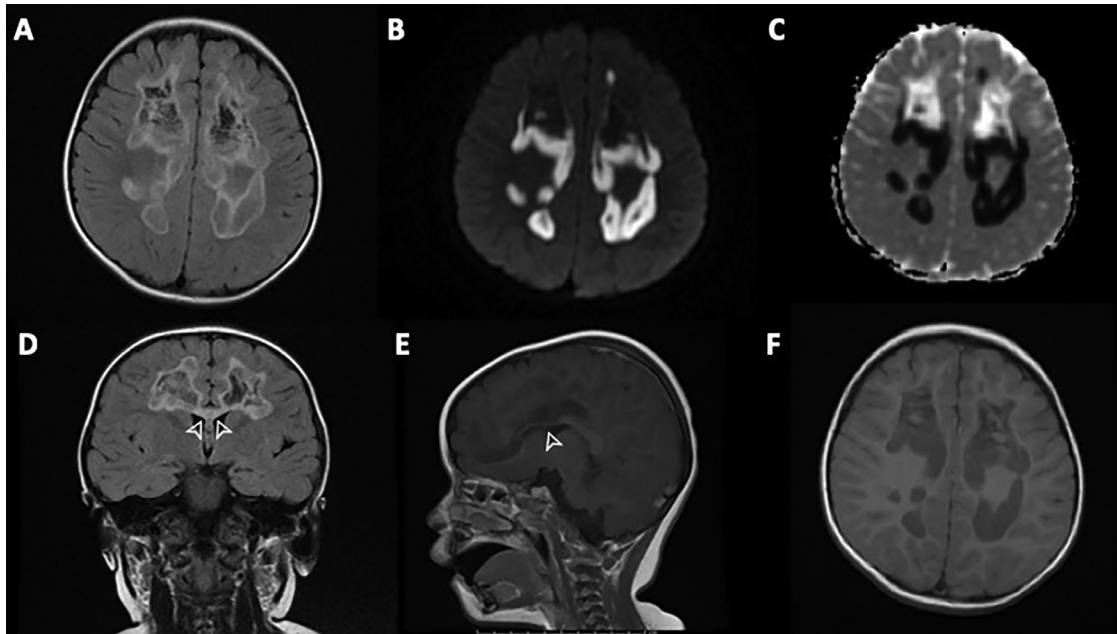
Brian MR images at 2 years and 4 months of age. A and D, Axial fluid-attenuated inversion recovery (FLAIR) image (A) and coronal FLAIR image (D) demonstrates a bilateral leukoencephalopathy with central cavitation and hyperintense rim involving the centrum semiovale and anterior corpus callosum (arrowheads). B and C, Axial diffusion-weight image (B) and apparent diffusion coefficient map (C) shows restricted diffusion in the peripheral portion of the affected white matter with increased diffusivity in the cavitations. E, Sagittal T1-weighted image shows involvement of the anterior corpus callosum (arrowhead). F, Axial T1-weighted image demonstrates sparing of the subcortical white matter (U-fibers). No abnormal enhancement was visualized on postcontrast images.
